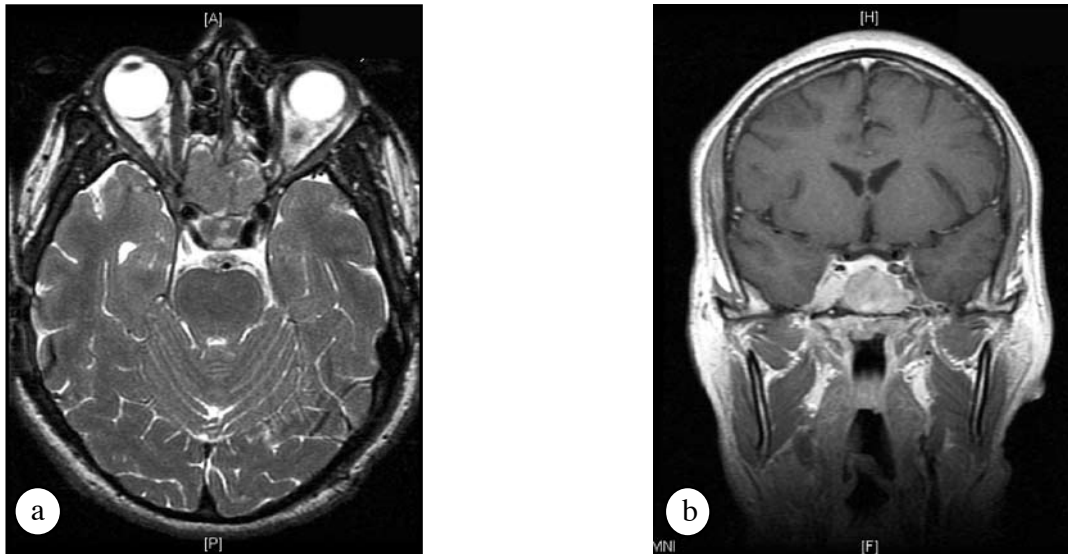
Brain MRI scans in a) axial T2-sequence, and b) coronal T1-sequence following IV gadolinium of a 45-year-old man with headache, facial numbness, and double vision.
